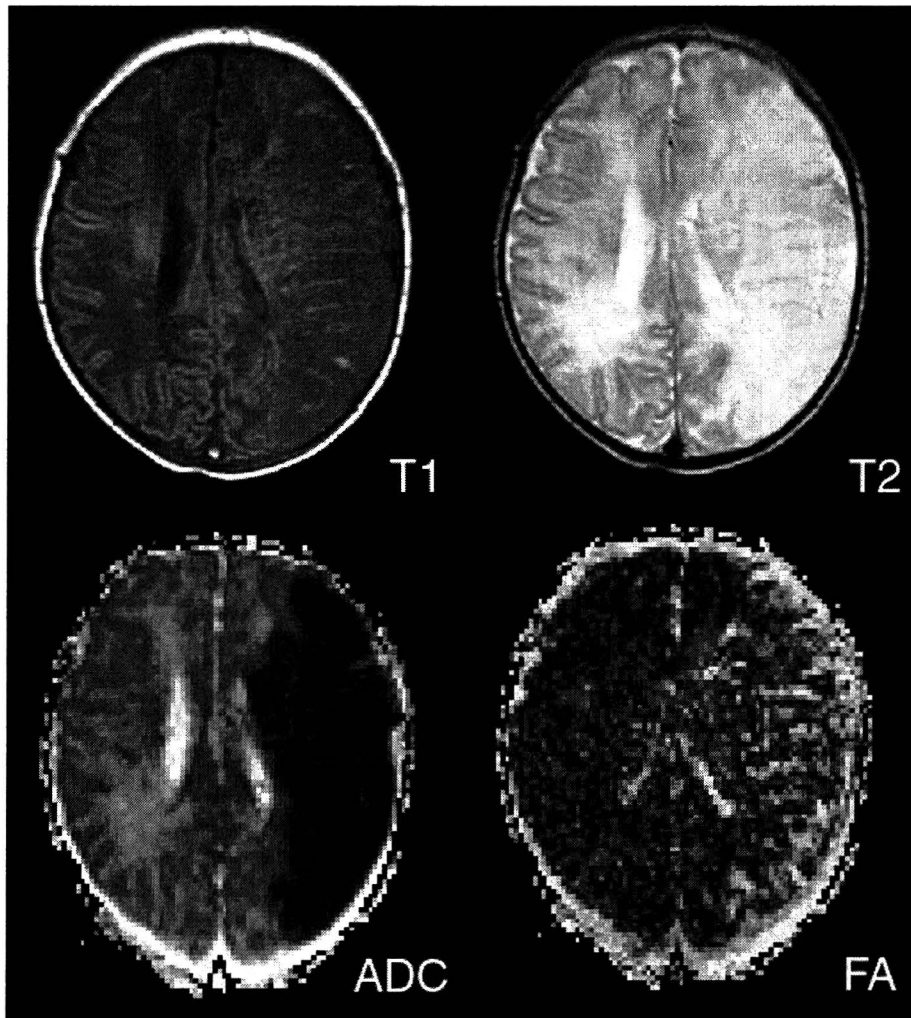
MR images of a neonate with a large ischemic brain lesion. Displayed are T_1 -weighted (T_1 , top left), T_2 -weighted (T_2 , top right), Apparent Diffusion Coefficient (ADC , bottom left) and Fractional Anisotropy (FA , bottom right) images. In the ADC image, a reduced diffusion in the ischemic region is evident as a dark region. The FA image shows an increased anisotropy in this region.
